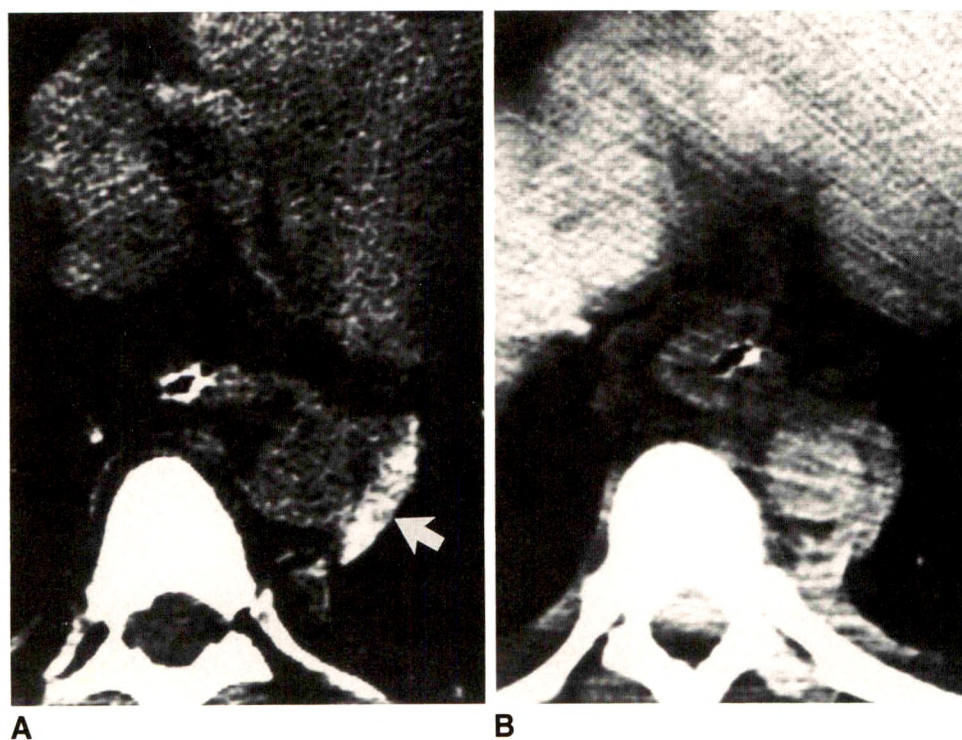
A and B, CT scans of abdomen. Periaortic hematoma (arrow), identified by its high density on non-contrast scan (A), became isodense and was misinterpreted as pleural fluid/hematoma on IV contrast-enhanced scan (B). Subsequent aortogram showed thoracic aortic tear, which was repaired surgically.
